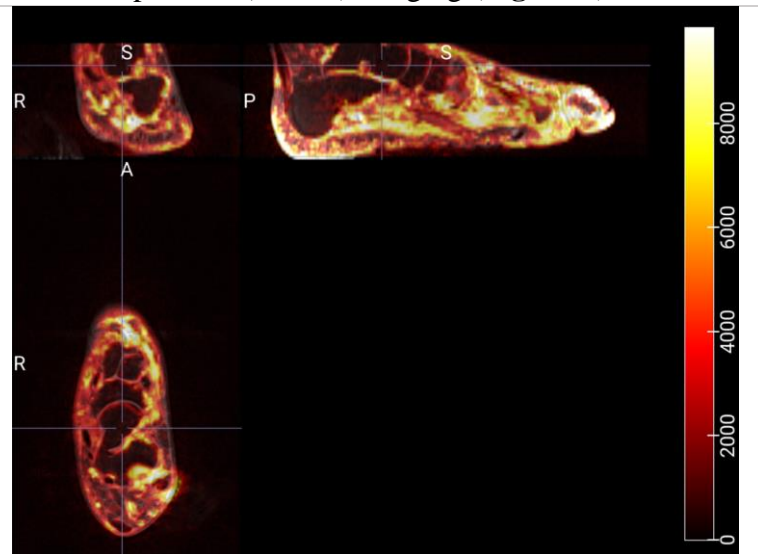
Representative volumetric reconstruction of BOLD MRI image contrast from a single time point (dynamic) in a DFU patient.
